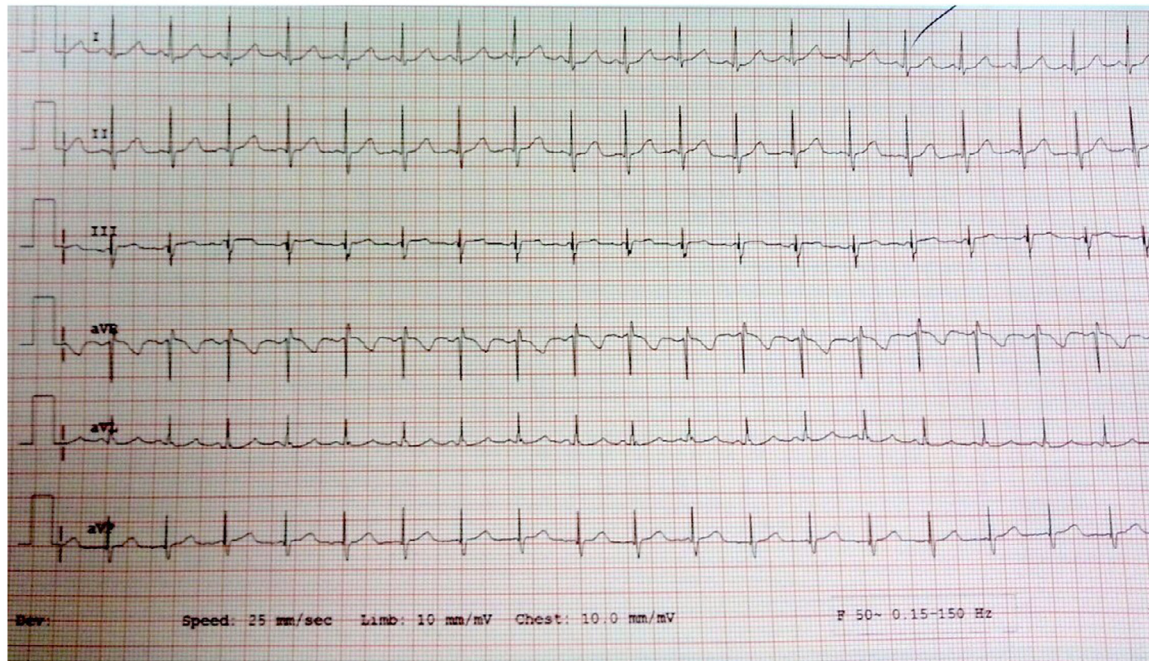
(A). Echocardiography before coronary artery fistula closure. (B) Echocardiography after coronary artery fistula closure, shows no changes in ST and T waves.
